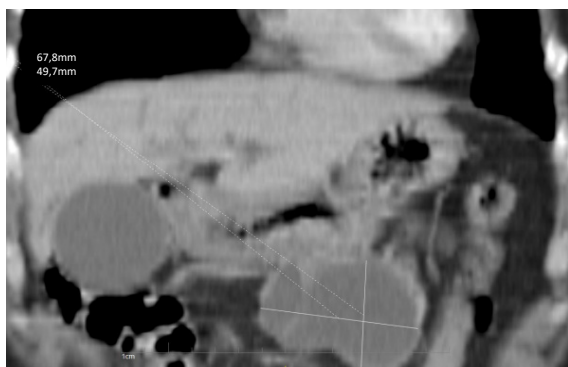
CT imaging confirmed the presence of a gastric gastrointestinal stromal tumor (GIST)
